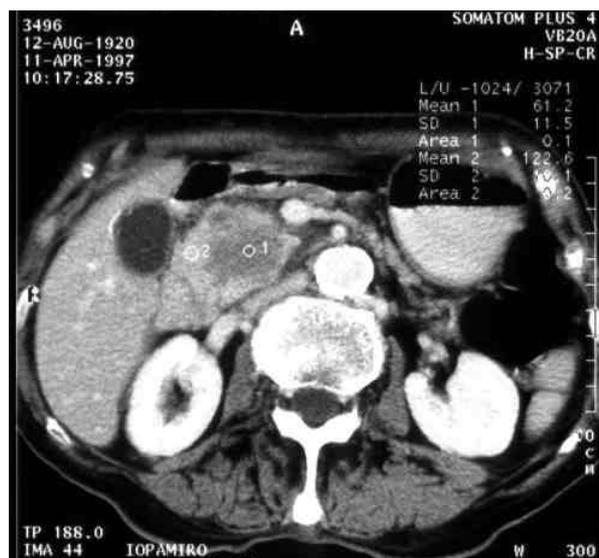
A 52 year old male with icterus. Spiral CT after contrast medium administration shows a hypodense 3 cm diametered lesion in the processus uncinatus. Ductal adenocarcinoma
